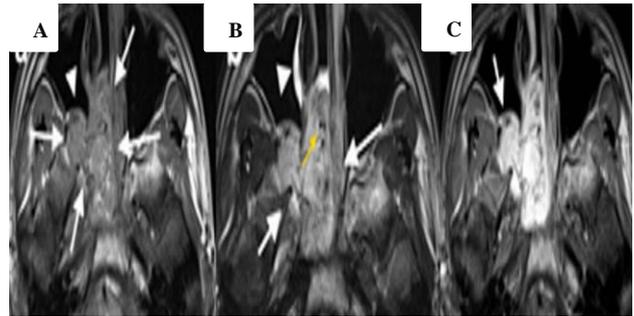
15-year-old male patient. (A) axial T1-weighted precontrast, (B) axial T2-weighted precontrast, and (C) axial T1-weighted postcontrast MR images demonstrate a right-sided nasopharyngeal mass.
